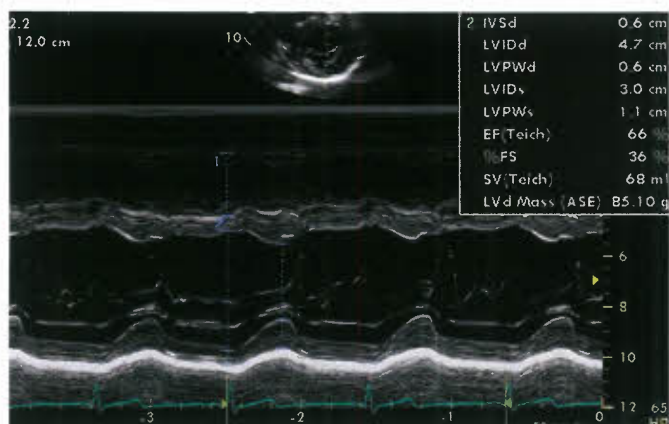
M-mode measurements. M-mode measurement is obtained from a parasternal short-axis view of the left ventricle just inferior to the mitral valve leaflets. End-diastolic (at the QRS complex) and end-systolic (at point of minimal diameter) measurements are obtained and fractional shortening and ejection fraction are calculated. EF, ejection fraction; IVSd, inter-ventricular septum at end diastole; LVPWd, left ventricular posterior wall thickness at end diastole; LVIDs, left ventricular end-systolic dimensions; %FS, percent fractional shortening; SV, stroke volume; LVD Mass, left ventricular mass.
